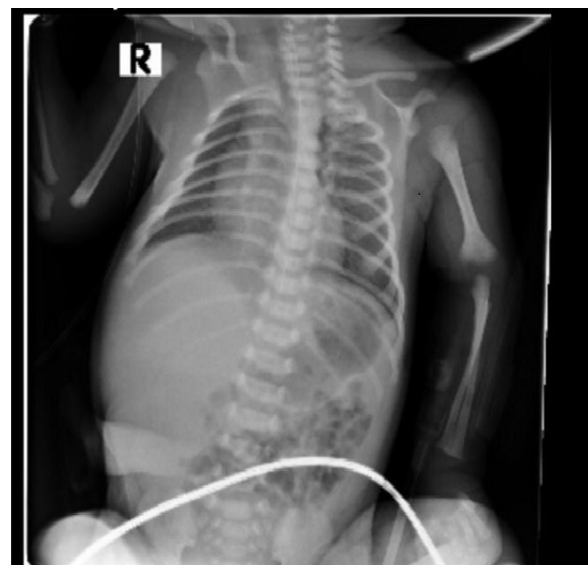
Chest X-ray of the newborn obtained on March 22, 2020
